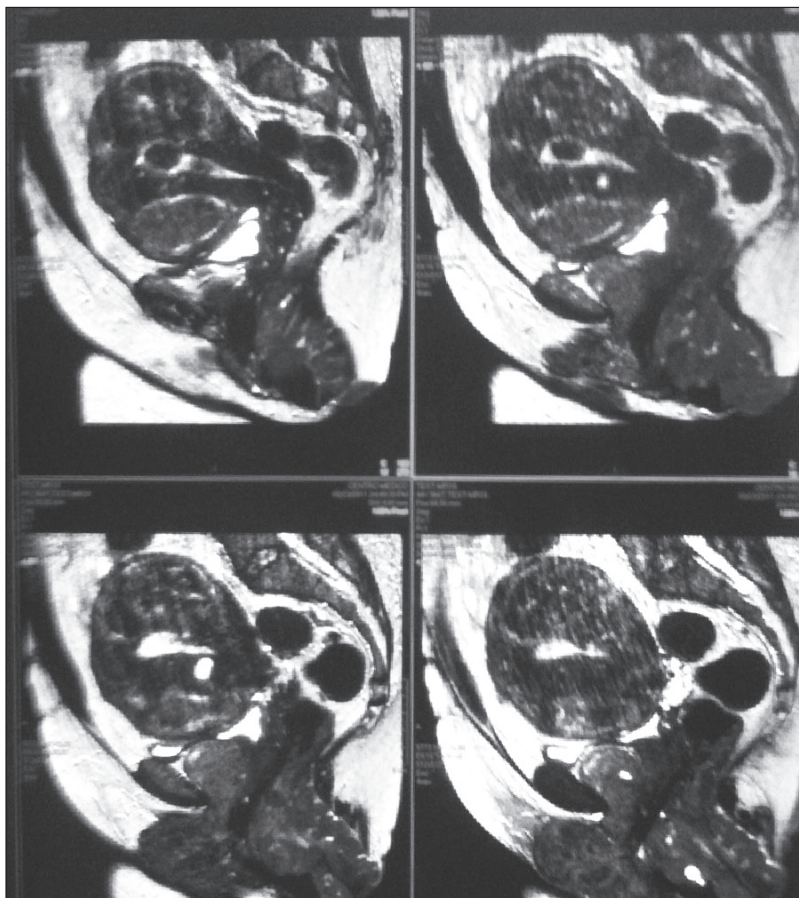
Pelvic MRI reveals an anteverted, enlarged, myomatous uterus (10.7cm long x 11.6cm AP x 9.6cm). Myoma sizes: posterior uterine body, 5.3cm x 4.5cm x 6.9cm; anterior uterine body, 3.3cm x 5.2cm x 3.8cm; and subserosal, 1.6cm x 0.8cm x 1.5cm. Enhancing complex mass associated with the anterior urethra, with a cystic component measuring 3.9cm, possibly secondary to diffuse leiomyomatosis; rectal prolapse.
